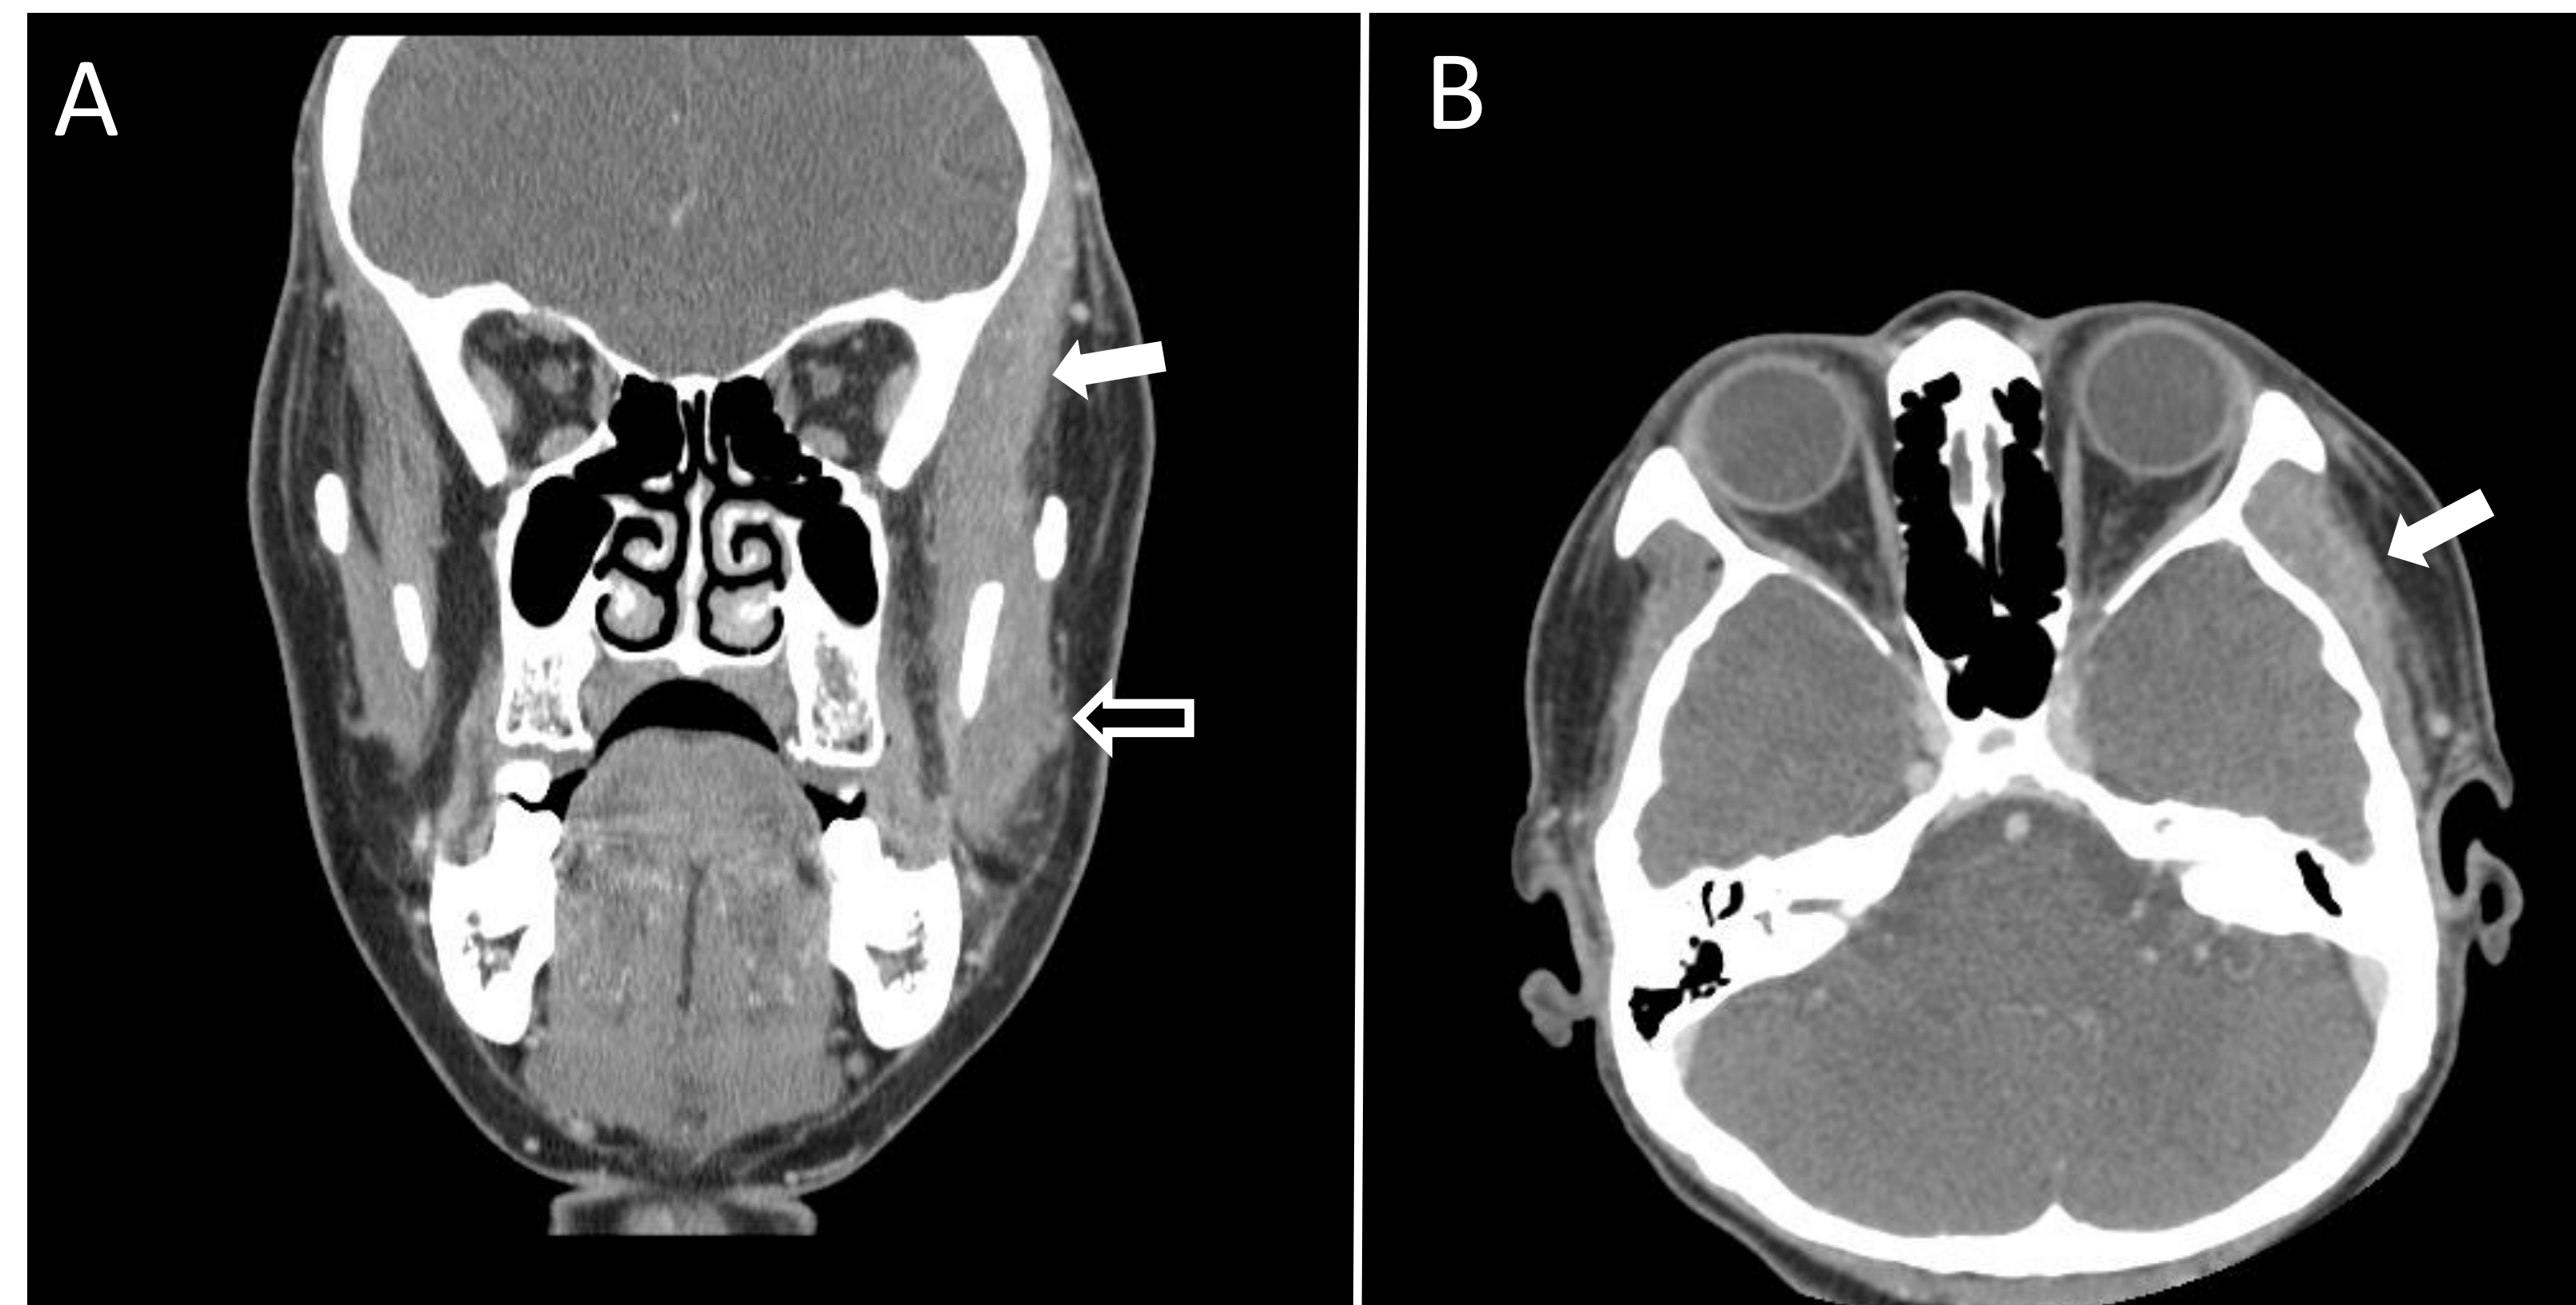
A) Coronal CT and B) axial CT imaging with contrast demonstrating diffuse thickening of the left temporalis (solid arrow) and masseter (hollow arrow) muscles without any discrete lesion. There is minor associated fat stranding in the left buccal subcutaneous fat.
